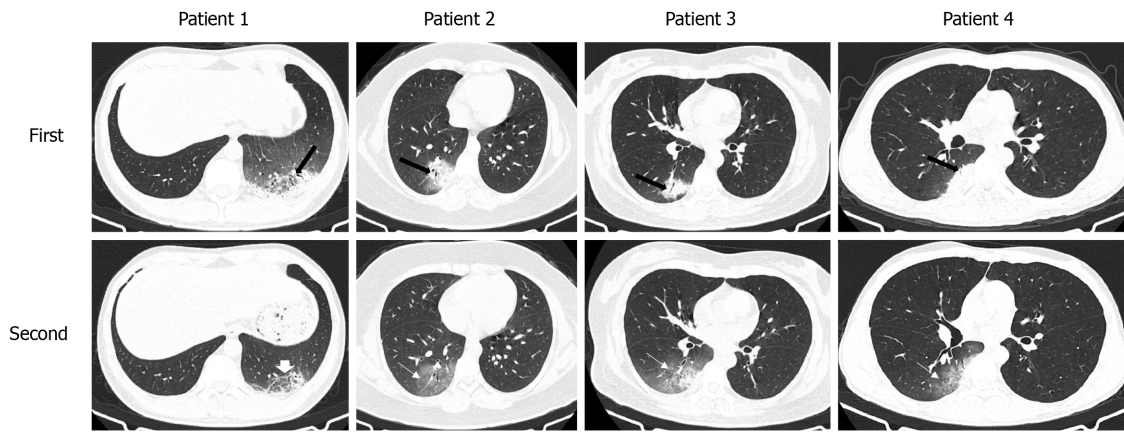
The imaging findings of 4 confirmed patients with psittacosis in cluster 1. The predominant lesions type of 4 patients are consolidation or mixed ground-glass opacity (GGO) and consolidation (black thick arrow). Air bronchogram is presented in all patients. On follow-up computed tomography scans, the consolidations are absorbed and the area of GGO is extended in patients 2-4 (thin white arrow). The area of lesions is reduced in patient 1 (short white arrow).
